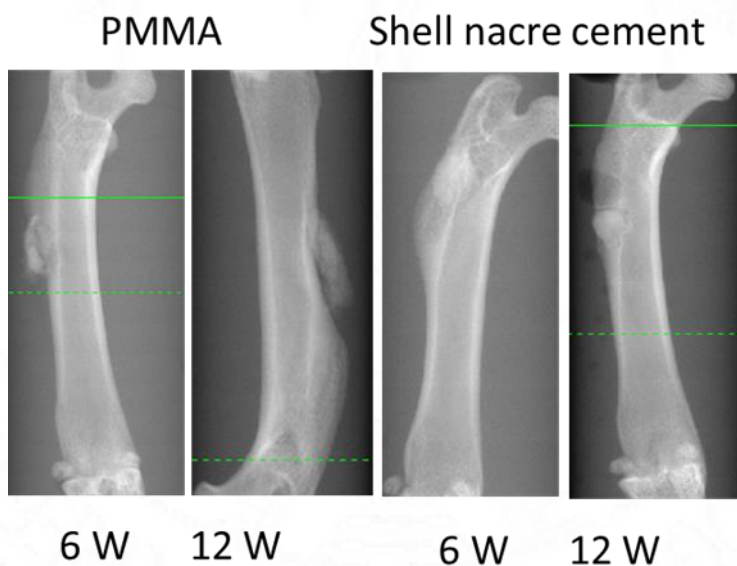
Radiography analysis after 6 and 12 weeks of surgery
